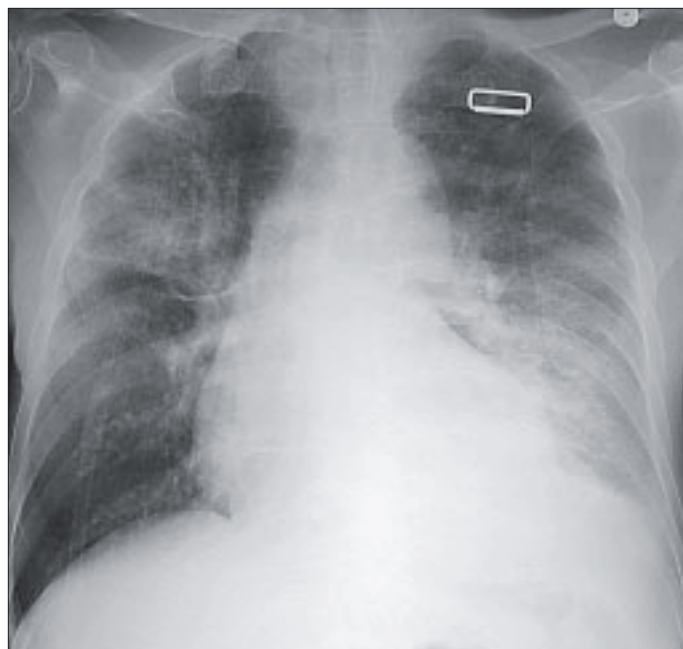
The chest radiograph taken of the patient after he was called back to the emergency department. Areas of consolidation are evident in the left lower lobe and right upper lobe. The pleural fluid was not significant in this image.
